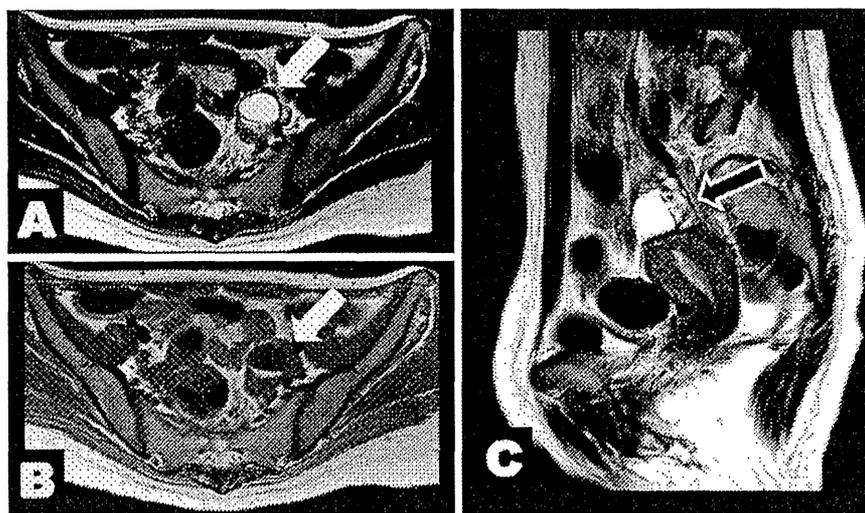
An ovarian lesion on pelvic MRI. A) Axial T2-weighted imaging. B) Axial T1-weighted imaging. C) Sagittal T2-weighted imaging. A small mass (26 mm in long diameter) was found in the left ovary (arrows).
